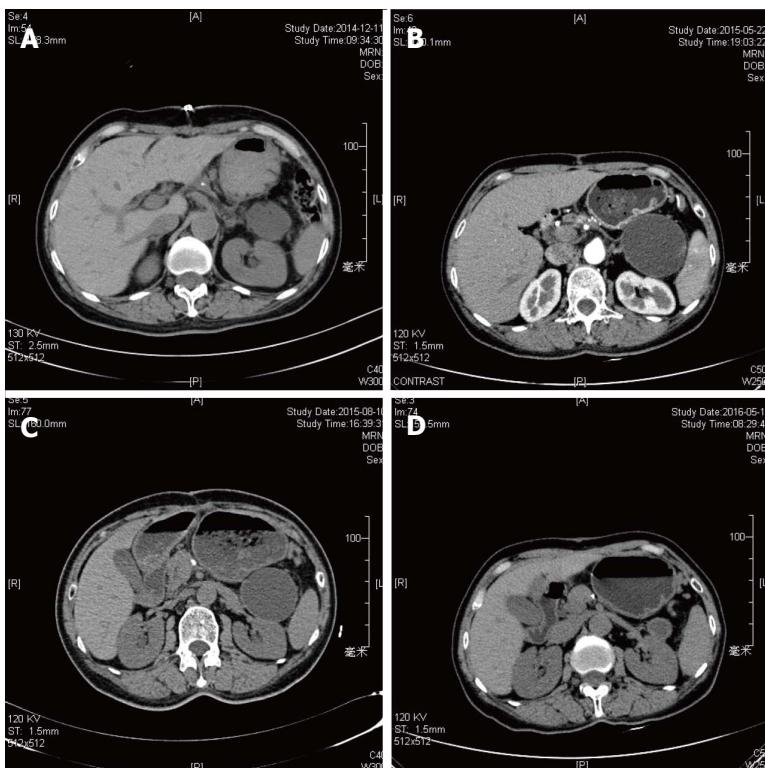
Failed case of pancreatic fluid collection drainage. A: Computed tomography (CT) scan after procedure (24 h); B: CT scan after procedure (72 h); C: CT scan after procedure (3 mo); D: CT scan after procedure (1 year).
